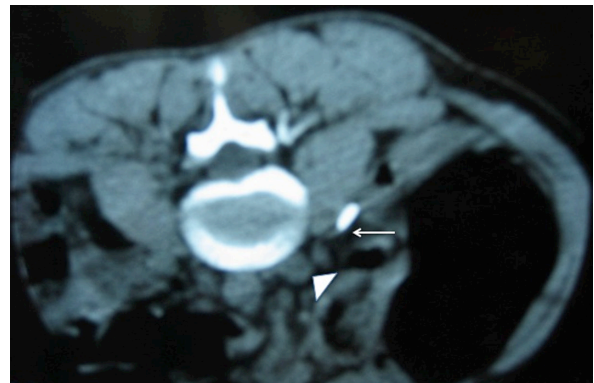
Computed tomography fluoroscopy showing the puncture needle (white arrow) approaching the infrarenal inferior vena cava (white arrowhead).
